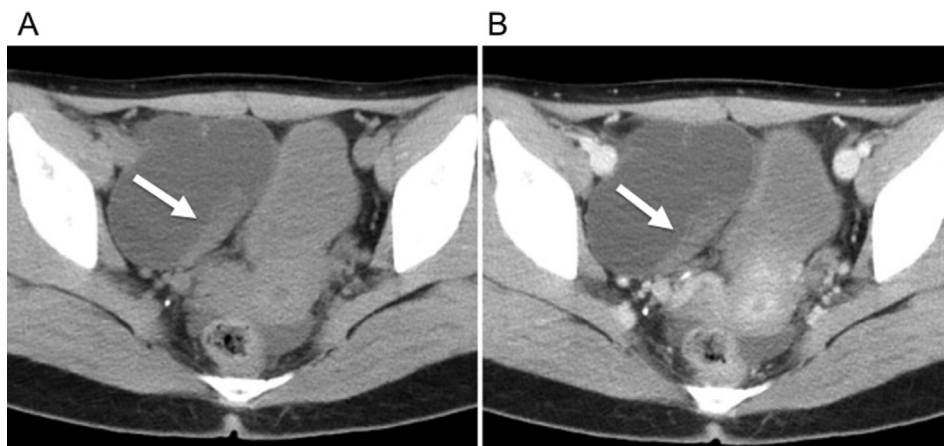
(A) Noncontrast pelvic computed tomographic image showing a cystic lesion in the anterior right pelvis. The partially thickened wall of the cyst shows slightly high attenuation (arrow). (B) Contrast-enhanced pelvic computed tomography scan showing poor enhancement of the cystic wall (arrow).
